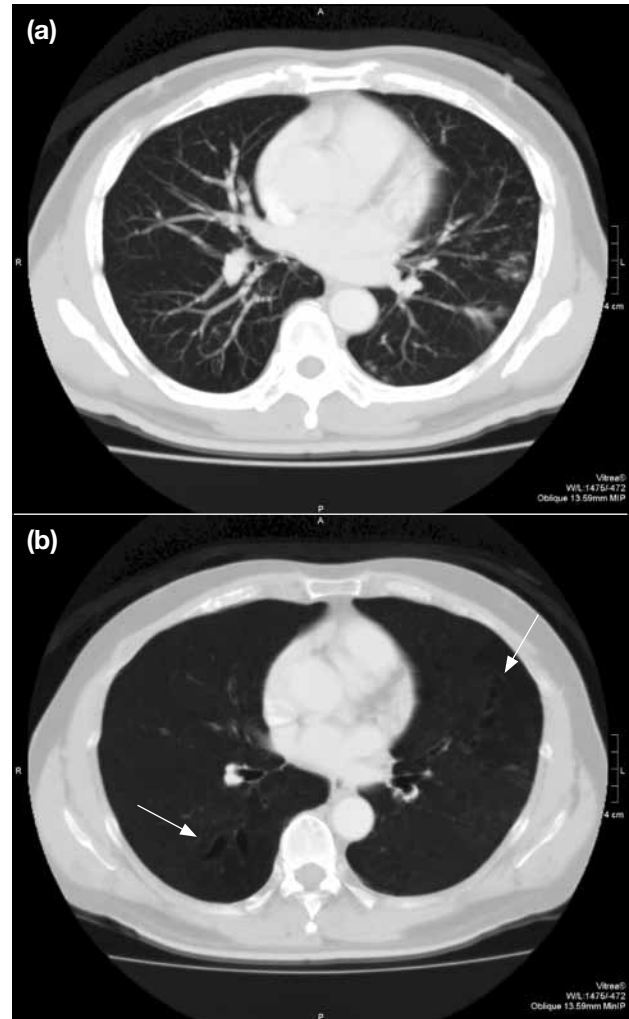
A male adult with bronchiectasis and negative results for mycobacterial or other bacterial infection: axial post-contrast computed tomographic scans of thorax (a) in a lung window with maximal intensity projection showing tree-in-bud opacities in the left lung, and (b) in a lung window with minimal intensity projection showing bronchiectasis (arrows) in the right lower lobe and left upper lobe.
